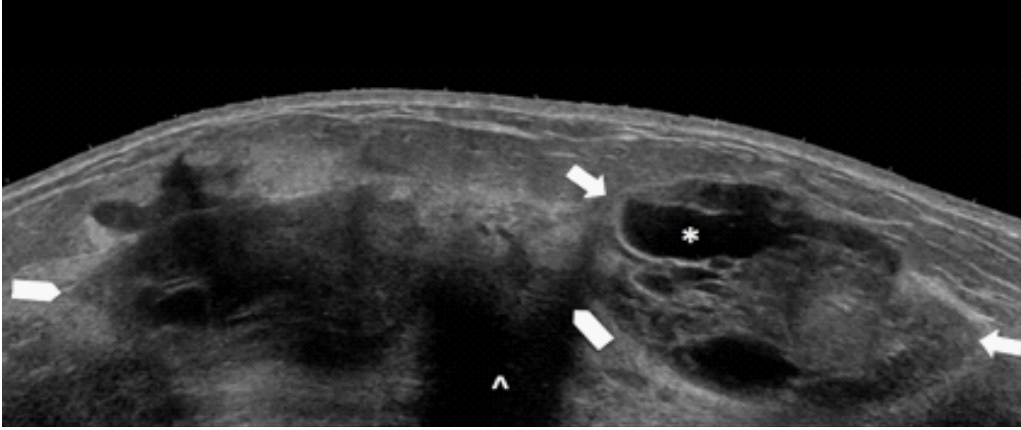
Large field-of-view ultrasound of a 17-year-old female with palpable right breast masses. The image shows a 6.5 cm, irregular, heterogeneous mass (arrowheads) with non-circumscribed margins and mixed posterior features with shadowing (^) within the upper outer quadrant. In addition, a 5.5 cm, oval, mixed solid and cystic (*) mass (arrows), with circumscribed margins and parallel orientation is present within the upper inner quadrant.
